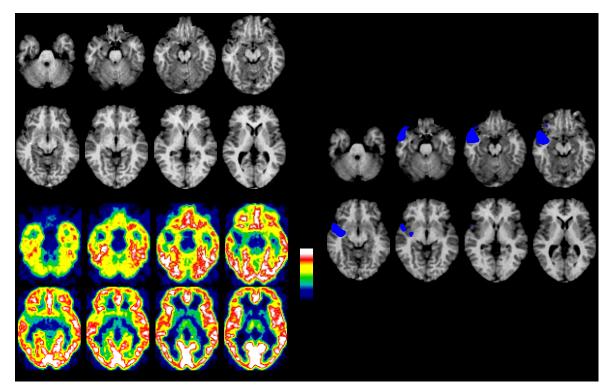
On the left of the figure is shown sections from a T1-weighted MRI of a patient with a right anterior temporal DNET (above) and coregistered ¹¹C-flumazenil PET from the same subject. Using statistical parametric mapping (SPM), an objective and automated means for comparing images, the right side of the figure shows (in blue rendered onto the MRI) the region having a significantly reduced flumazenil binding compared with 24 normal controls.
